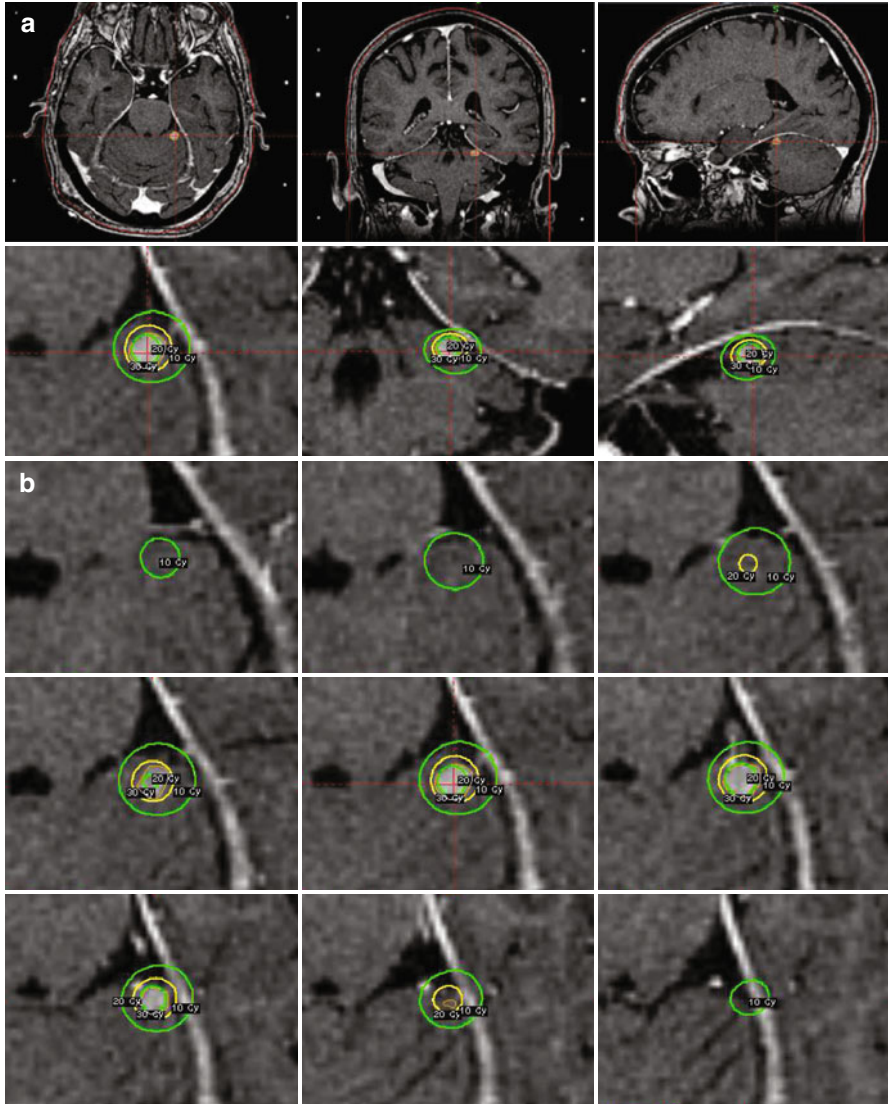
SRS treatment of a cerebellar lesion in close proximity to the brainstem. (a) Axial, coronal, and sagittal slices from a volumetric (1 mm) contrast-enhanced MRI through the center of the metastatic lesion, contoured in orange. The 20-Gy prescription isodose line is shown in yellow, with 30 Gy and 10 Gy lines in green. (b) Serial axial images delineating the entire volume receiving 10 Gy. The sharp dose falloff allows treatment of this lesion adjacent to the brainstem (see Table 27.2 for dose constraints).
